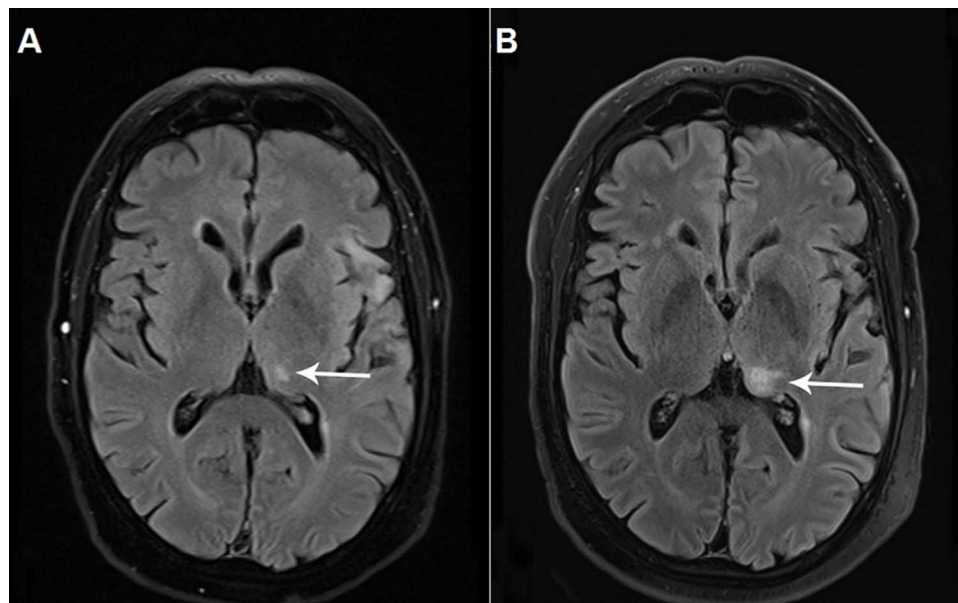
Axial FLAIR image (A) after rechallenge shows a new small T2 hyperintensity lesion in the left thalamus (white arrow) and recurrence of T2-hyperintensities in the left insular cortex. Axial FLAIR image (B) at the second recurrence of clinical relapse clearly shows an increase in size of the thalamic T2-hyperintensity lesion (white arrow).
